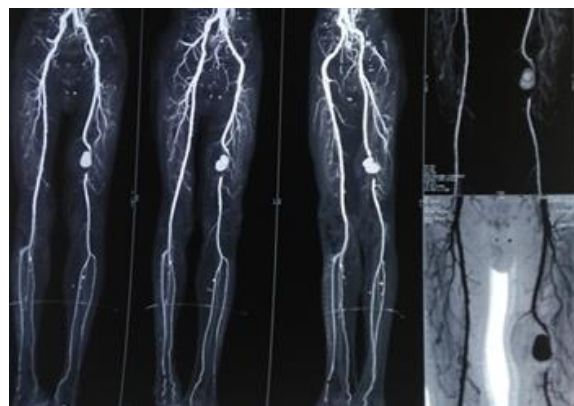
CT angiogram showing pseudoaneurysm of left mid and distal superficial femoral artery.
